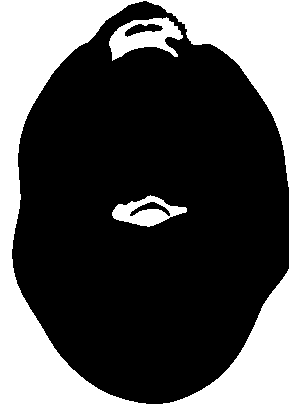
The second sample of CT scans on the top view after segmentation.
